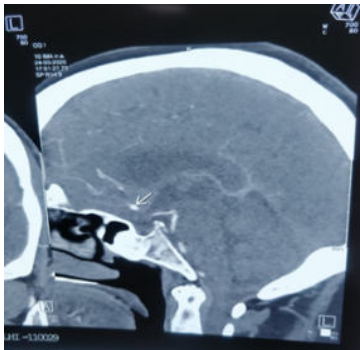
Sagittal view of CT angiography of brain showing ACoM aneurysm
